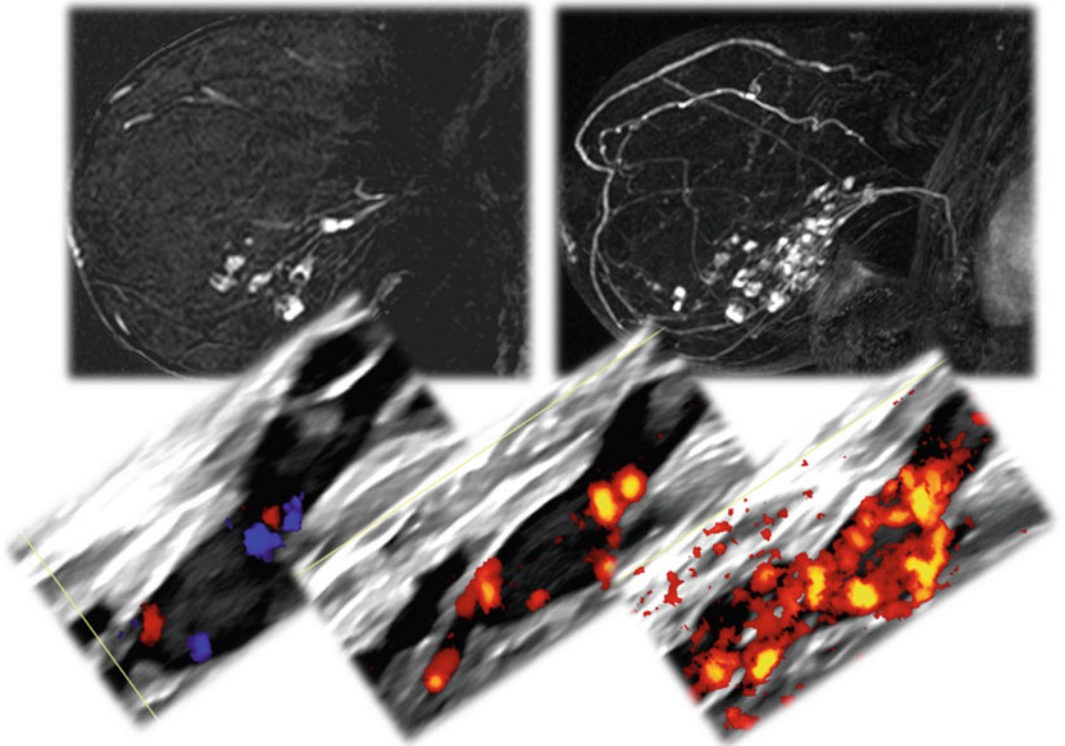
DCIS: MRI shows regional stippled enhancement. Targeted ultrasound reveals intraductal hypervascular tissue
